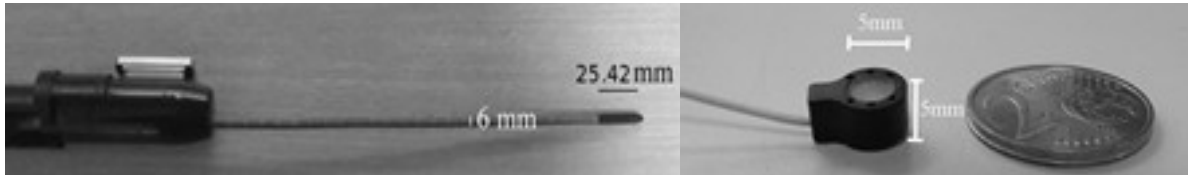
Left: ultrasound probe. Right: ultrasound marker
